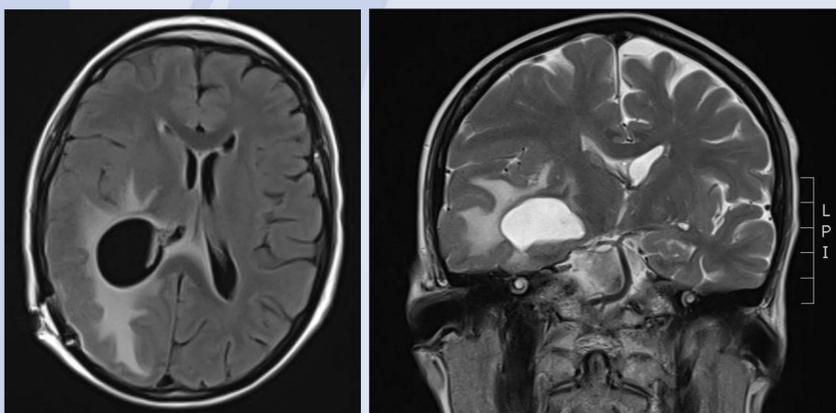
MRI appearances at presentation in January 2017
